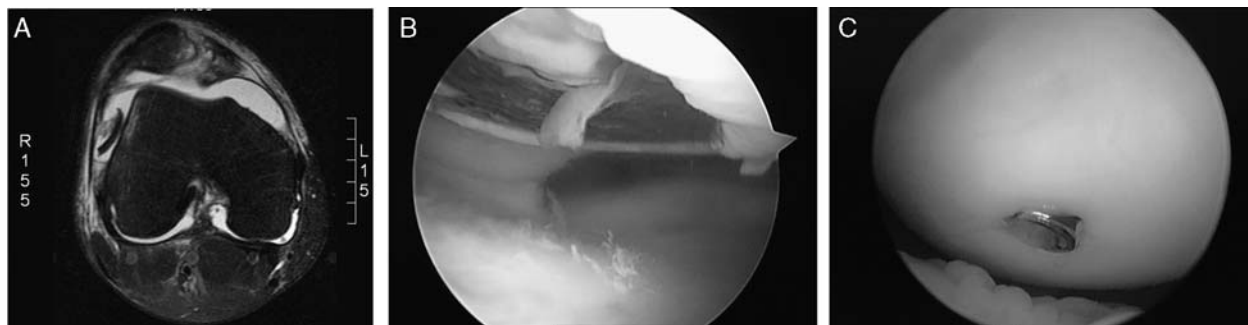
A, Axial magnetic resonance image showing displaced osteochondral fragment from lateral femoral condyle in 20-year-old lacrosse player who sustained a traumatic patella dislocation. B, Arthroscopic image of the lateral femoral condyle defect before debridement and fixation of lesion (through lateral parapatellar arthrotomy). C, Headless screw visible at the time of screw removal (12 wk).
